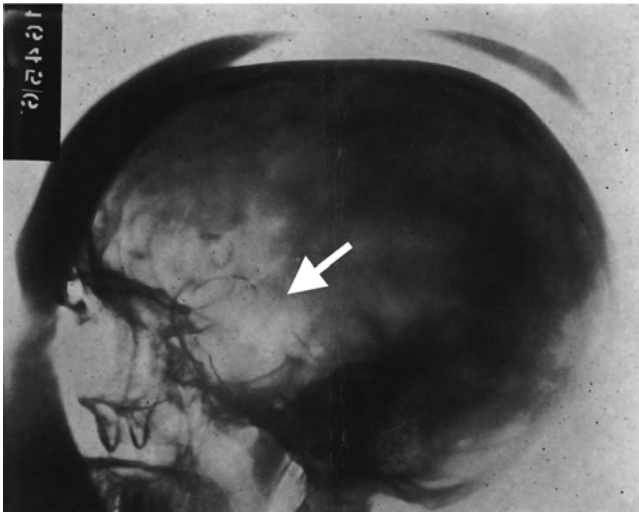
Radiograph obtained by Heuer and Dandy showing calcified intracranial aneurysm (arrow added). (Reproduced from Heuer GJ, Dandy WE: A report of seventy cases of brain tumor. *Bull Johns Hopkins Hosp* 27:224–237, 1916.)
